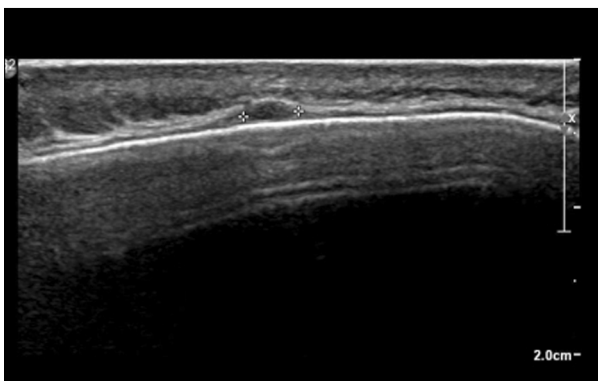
Ultrasonography of the scalp. The tumor is shown on the aponeurosis as a hypoechoic mass.
